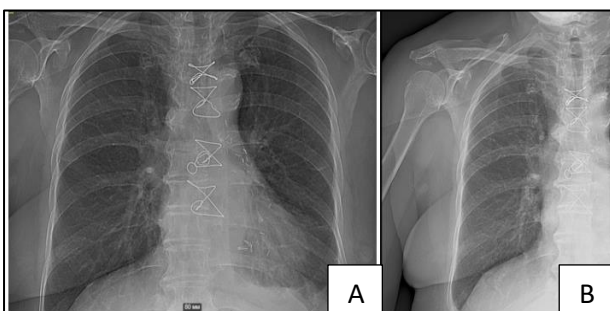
(A and B): Patient's X-Ray showing signs of left lobar pneumonia in basal segments and small bilateral effusion.
